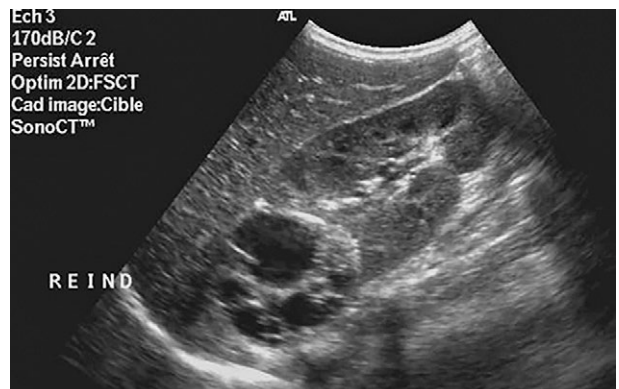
Renal hydatid cyst of the right kidney type III of Gharbi's classification was identified in a 13-year-old boy who presented with pain in the right flank: longitudinal ultrasound scan shows a multi-septated cystic structure in the upper pole of the right kidney.
